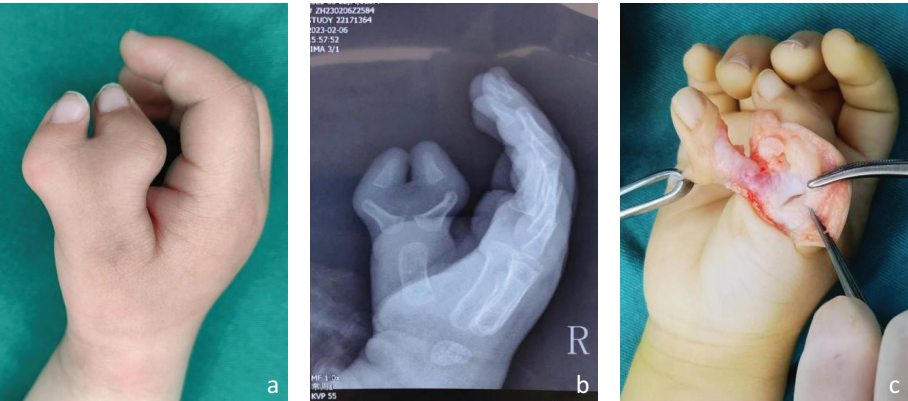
Inaccuracy of Wassel classification based solely on radiographs. (a, b) Clinical appearance and radiograph suggestive of Wassel type IV-D. (c) Intraoperative exploration confirming Wassel type III anatomy with cartilaginous connections between the phalanges.
